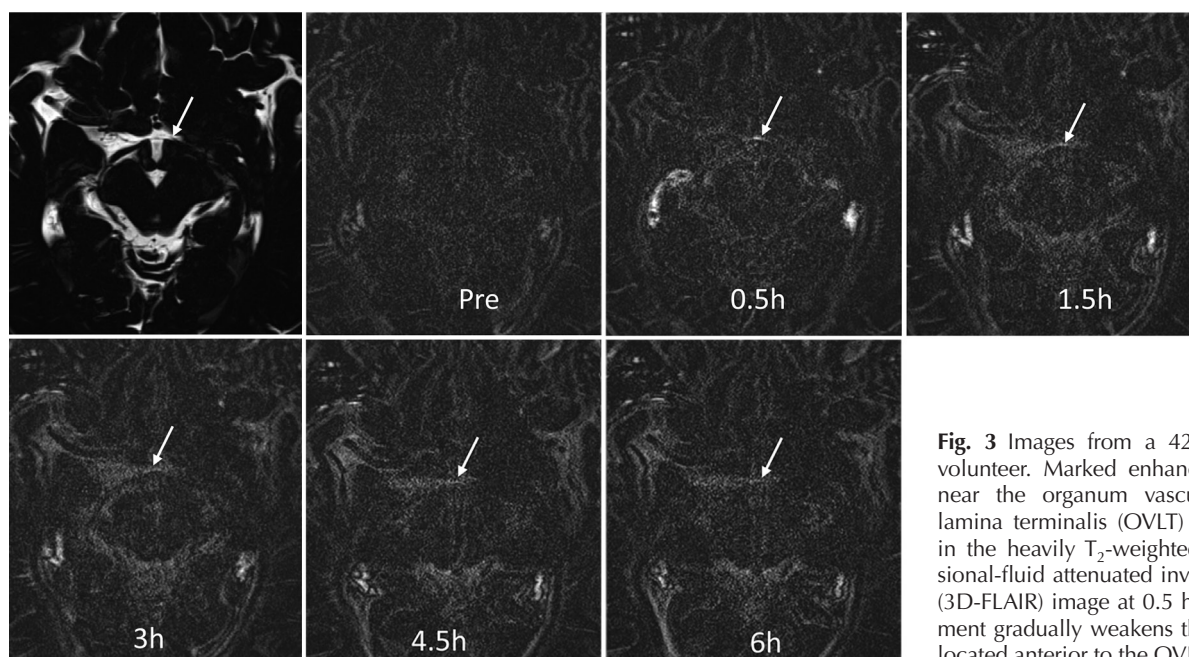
Images from a 42-year-old male volunteer. Marked enhancement (arrow) near the organum vasculosum of the lamina terminalis (OVLT) was visualized in the heavily T_2 -weighted three dimensional-fluid attenuated inversion recovery (3D-FLAIR) image at 0.5 h. The enhancement gradually weakens thereafter and is located anterior to the OVLT itself.
